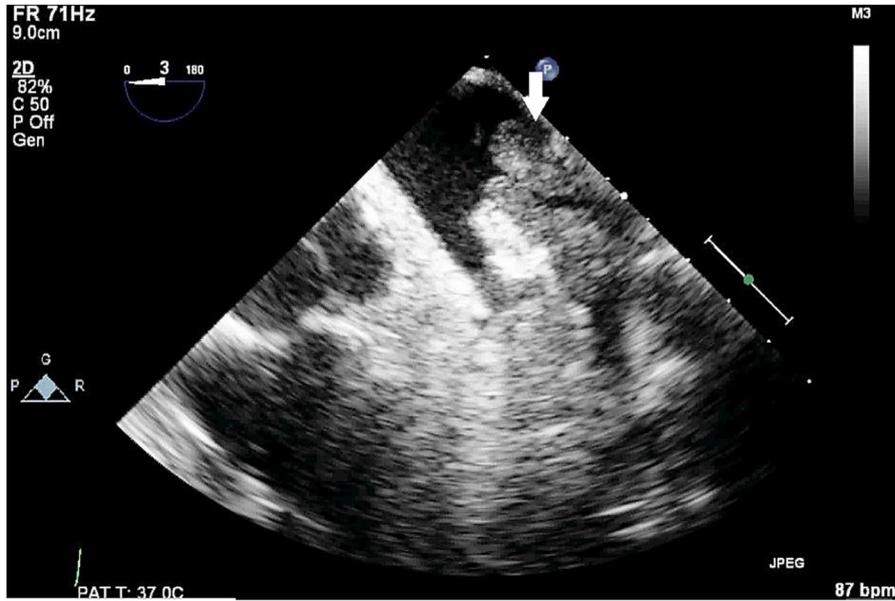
Trans-esophageal echocardiogram showing large thrombus burden at the ostium of left upper pulmonary vein.
